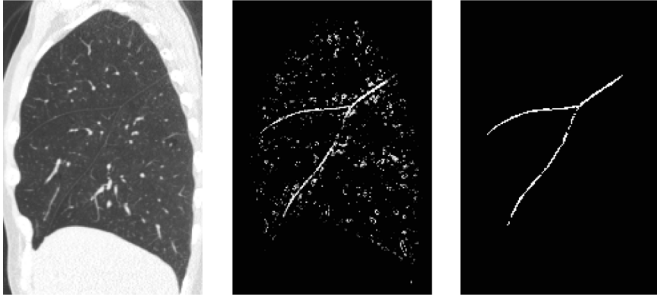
Example of the fissure segmentation, (a) the original CT slice, (b) result of supervised enhancement, (c) the final fissure segmentation.
